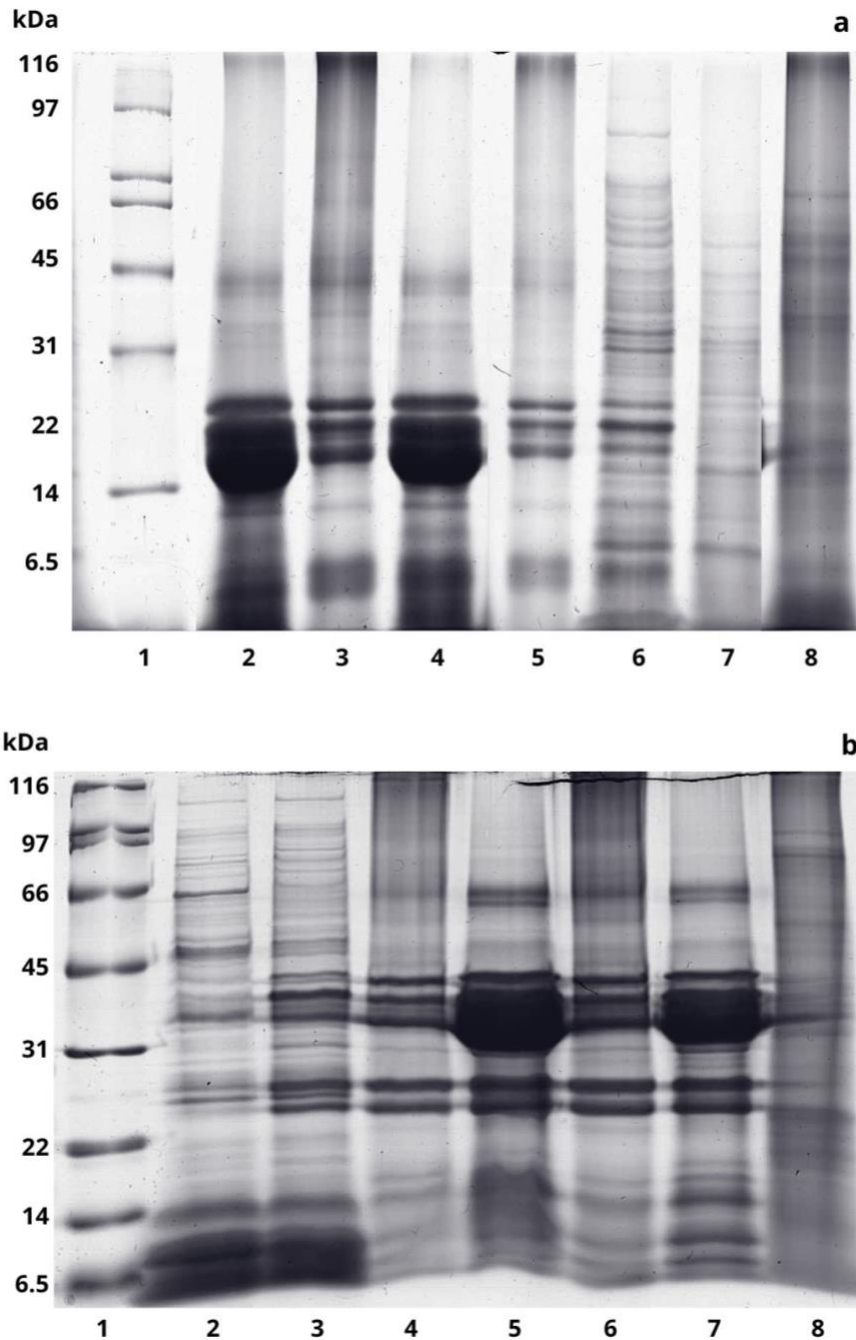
SDS-PAGE (18% acrylamide separating gel) of total ultrasound-assisted protein extracts from Sacha Inchi and Soy in the absence (a), and presence (b) of a reducing agent (2% v/v of β -mercaptoethanol). (1) SDS-PAGE standard broad range (Bio-Rad); (2) usSI7= ultra-sound SI at pH7; (3) usSI9= ultra-sound SI at pH9; (4) usSI11= ultra-sound SI at pH11; (5) SI11= SI with just pH 11 adjustment; (6) SI11h= SI at pH11 and heated; (7) usSI11c= cold ultra-sound SI at pH 11; (8) usSOY11= ultra-sound Soy at pH11.
